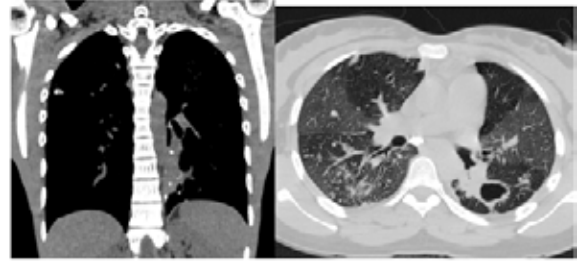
(a) Coronal reformatted image in a 20 yr old male patient on MDR-TB treatment since 8 months showing calcified granuloma in the right upper lobe and left lower lobe. (b) Axial HRCT image in a 36 yr old female on treatment since 2 days showing extensive mosaic attenuation in both lungs, thick walled cavity in the left lung and a calcified sub-carinal lymph node.
